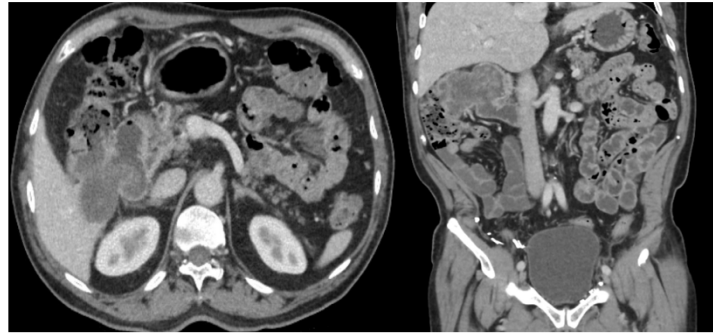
Contrast enhanced axial and coronal CT images in portal venous phase showing tumour arising from hepatic flexure and fistulising to second part of deodenum.
